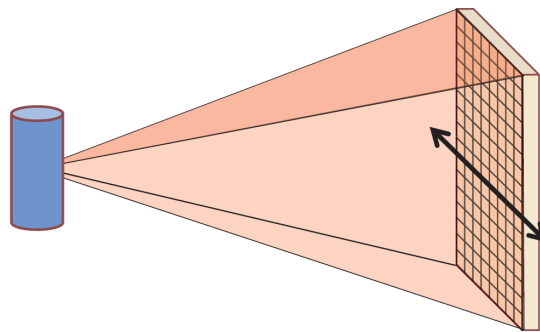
Cone Beam CT using a flat panel detector [11], this beam geometry is used in linac-mounted CBCT imagers.
